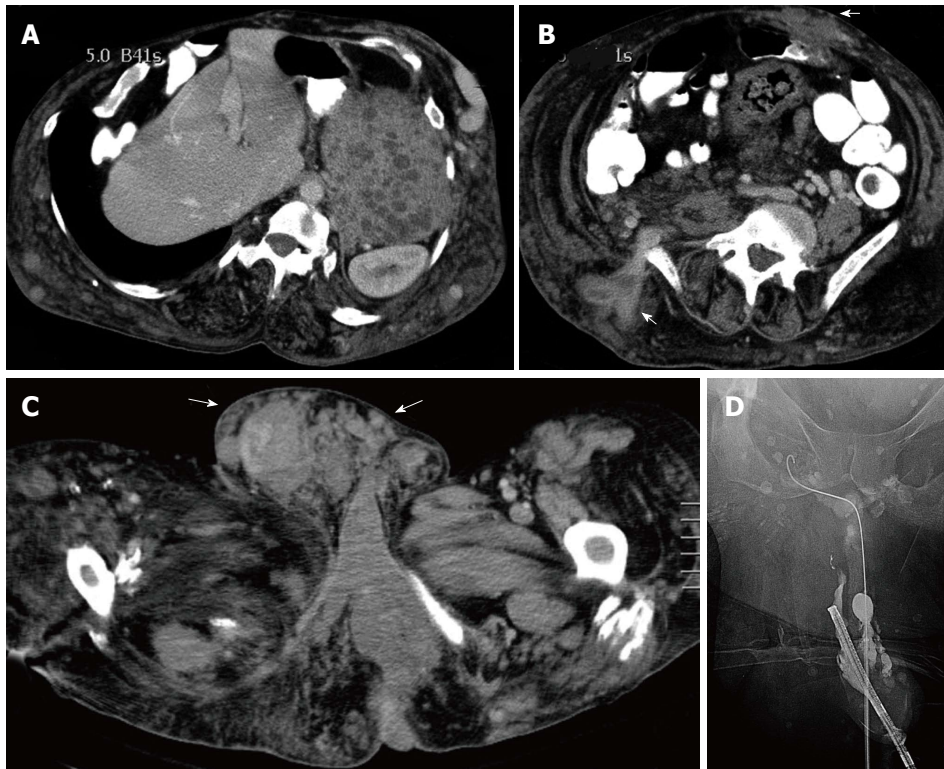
Klippel Trenaunay Syndrome. CT scan of the abdomen in a patient with the Klippel Trenaunay syndrome demonstrating extensive venous malformation in the abdominal wall (arrows) as well as venous malformations in the spleen (asterisk) (A, B). CT scan of the pelvis demonstrating extensive venous malformation in the inguinal canal and scrotum (arrows) (C). Sclerotherapy was performed through the dorsal vein of the penis to treat intractable urethral hemorrhage (D).
